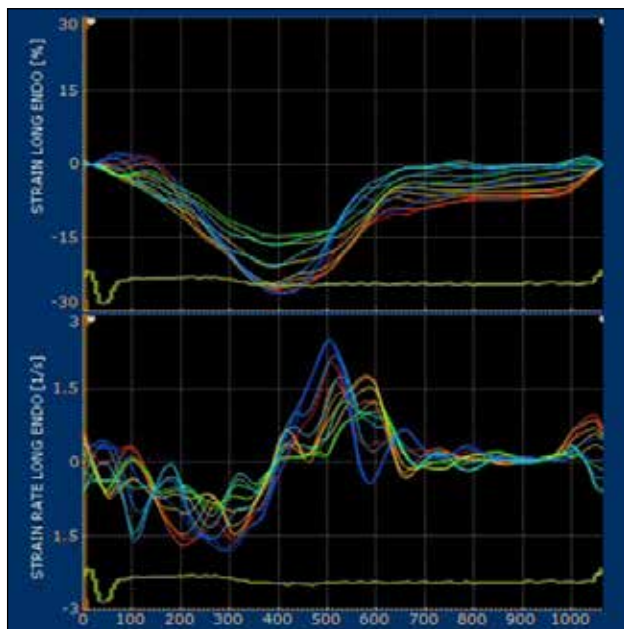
Segmental longitudinal strain and reconnoitering curves (distinctively coloured curves for left ventricular wall segments) obtained from apical 4-chamber views by speckle-tracking 2D-strain imaging. Global longitudinal strain and reconnoitering were obtained by averaging all segmental longitudinal strain curves computed from the conventional apical two-, three- and four-chambers views.
